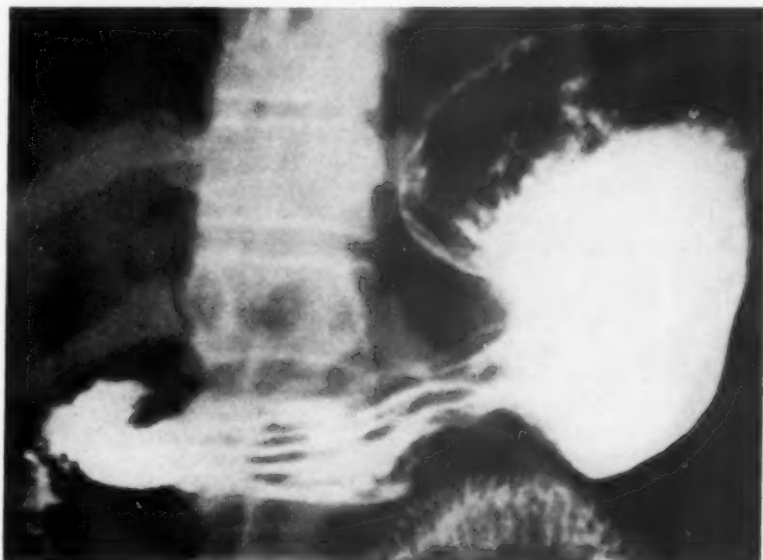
Roentgenogram of stomach postoperatively showing smooth notching of greater curvature at site of surgical removal of the polyp.
